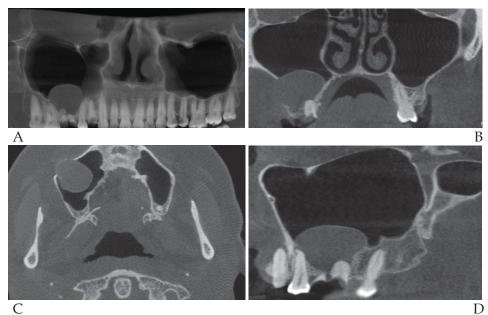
A) OPG image from CBCT; B) CBCT image, coronary section; C) CBCT image, axial section; D) CBCT image, sagittal section
